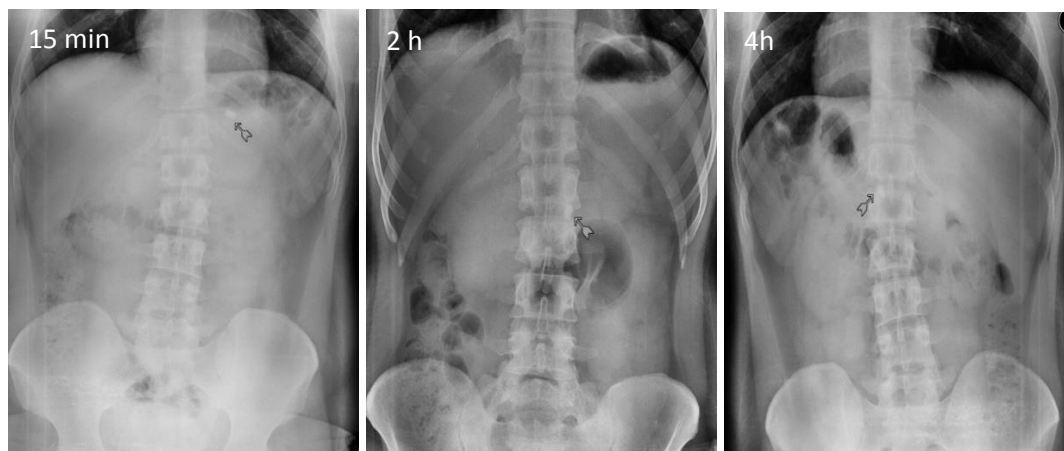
Representative x-ray photographs of *in-vivo* floating behaviour of gastro-retentive tablet at 0.25, 2 and 4h.
